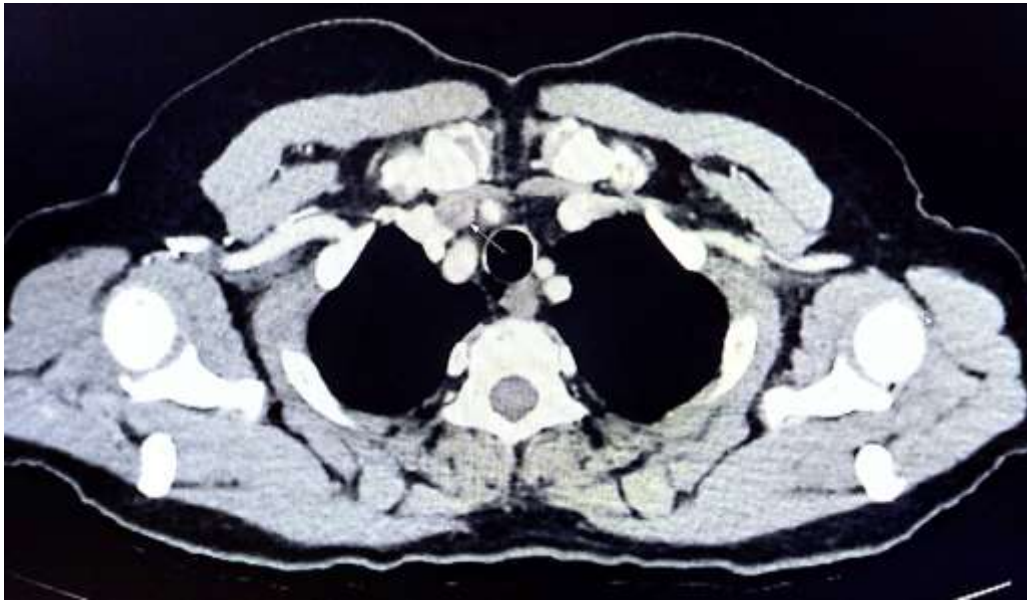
CT scan image of the patient showing a right paratracheal parathyroid nodule (arrow) (performed at Hassan II University Hospital, Fez, Morocco)
